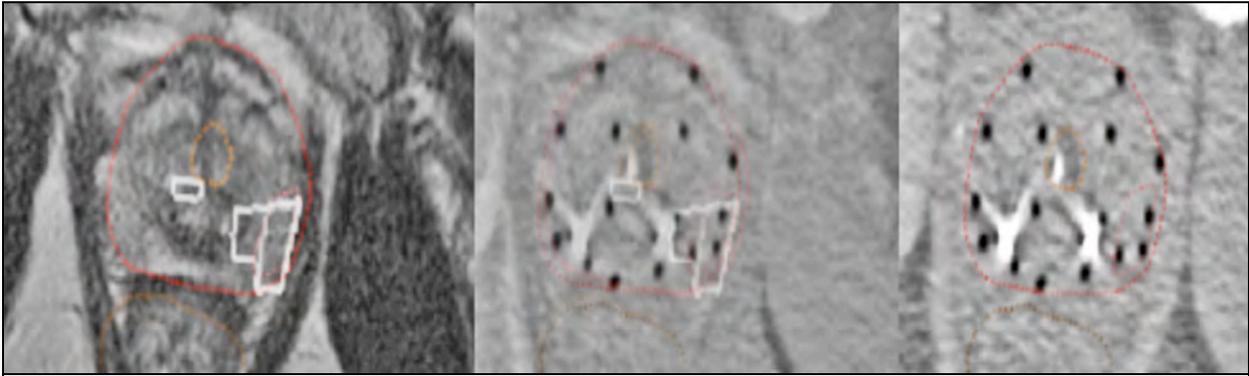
Adjusting transparency between MRI (left), MRI/CT 50-50 (center) and CT (right).
